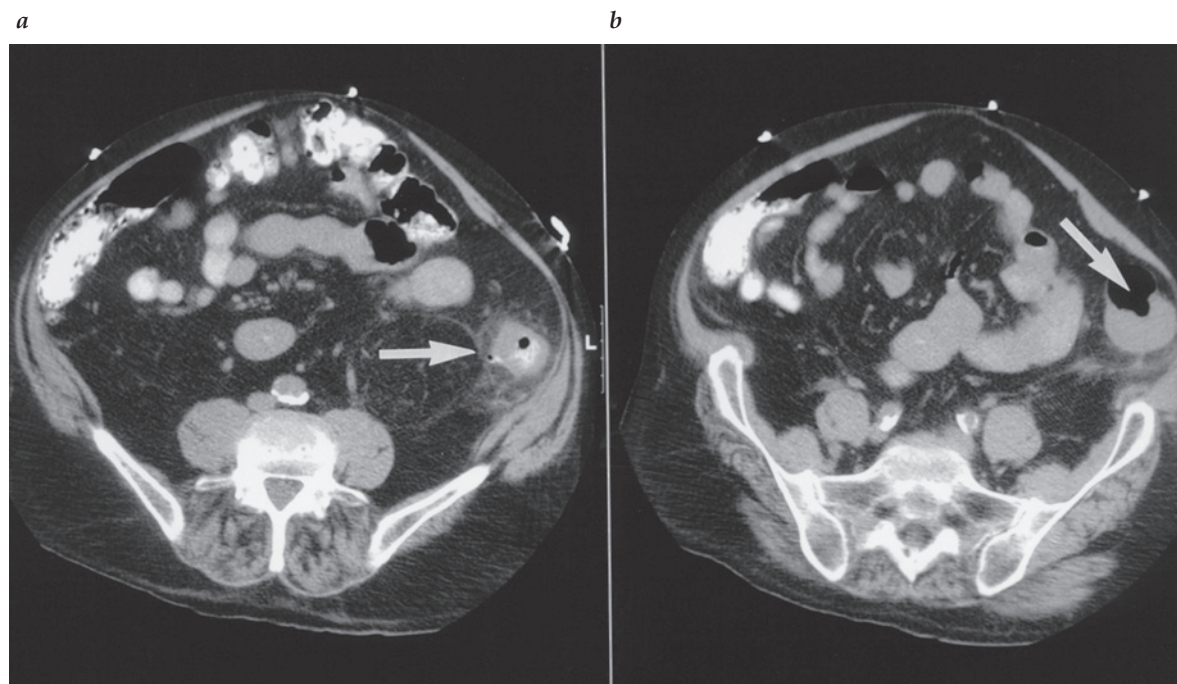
(a) Computed tomographic (CT) scan shows a thickened left colonic wall and diverticulum (arrow). Diverticulitis was considered the most likely diagnosis. (b) CT scan through an adjacent plane shows deformity of the mucosa, suggesting a possible apple-core lesion (arrow). Subsequent endoscopy revealed a carcinoma that was obstructing the colon almost completely.
